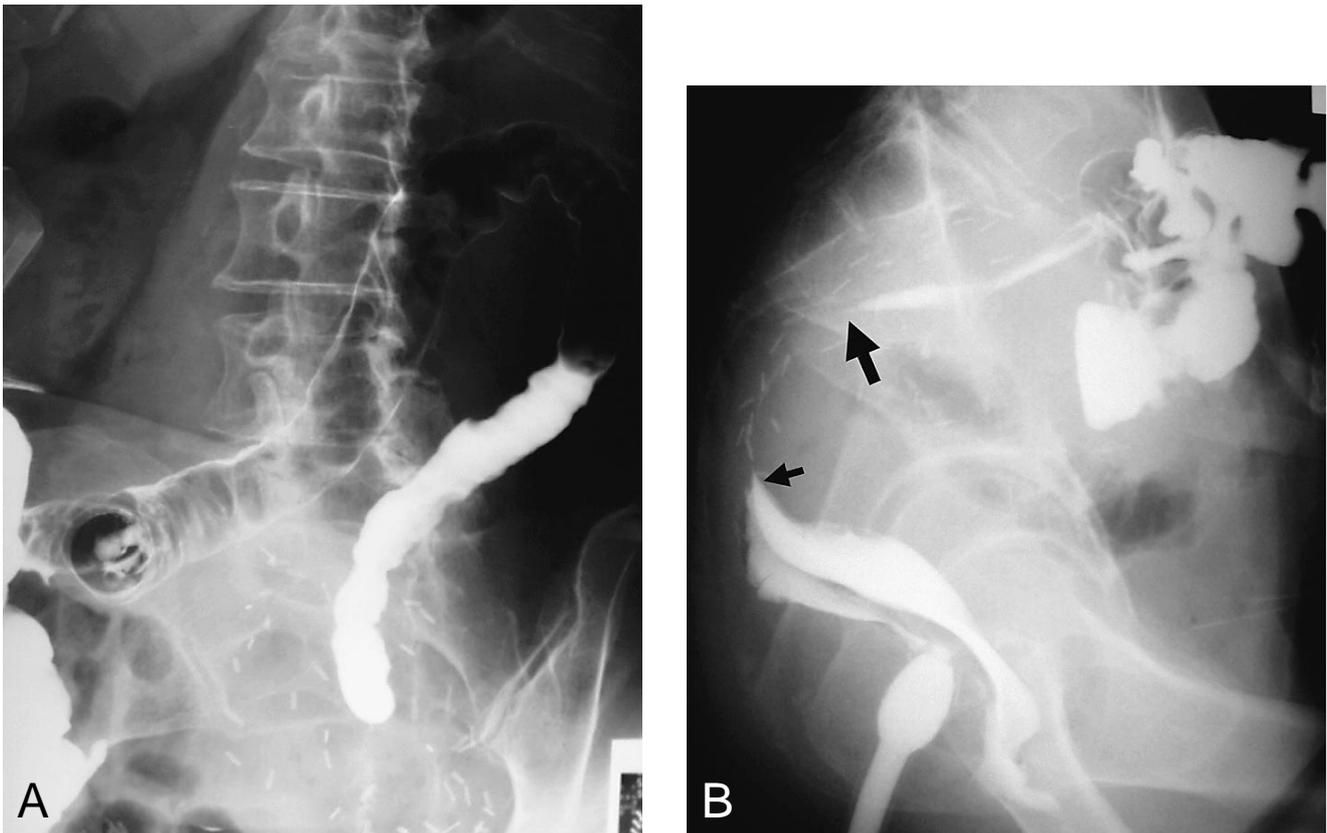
X-ray examination after low anterior resection for rectal cancer revealed formation of the rectovaginal fistula and obstruction at the colorectal anastomotic site.
